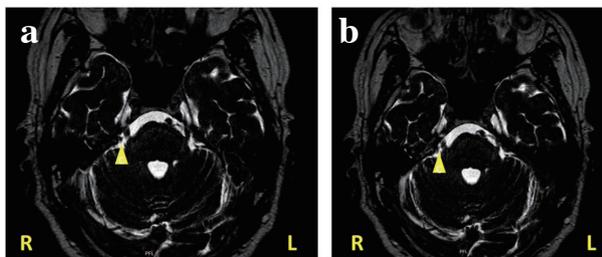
a, b: MRI scan showing neurovascular compression at the root entry zone, the right trigeminal nerve (RTN), and the superior cerebellar artery (SCA). R: right, L: left
